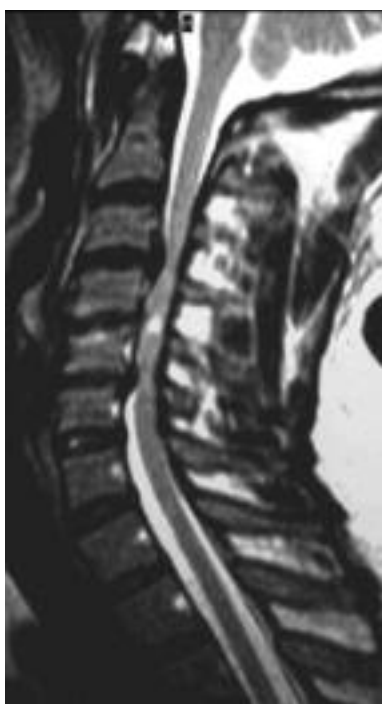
Magnetic Resonance imaging performed ten years later, in 2005. T2-weighted sagittal image showing a large disc herniation at C3/C4 causing spinal cord compression and a smaller disc herniation indenting the spinal cord at C5/C6. High signal changes are seen within the spinal cord at C4/C5.
